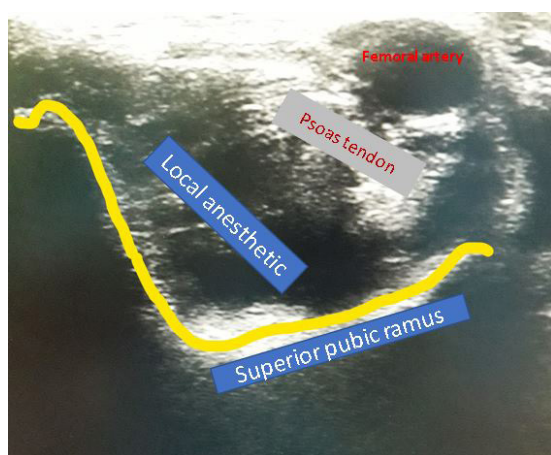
Ultrasound image after administration of the pericapsular nerve group block.
